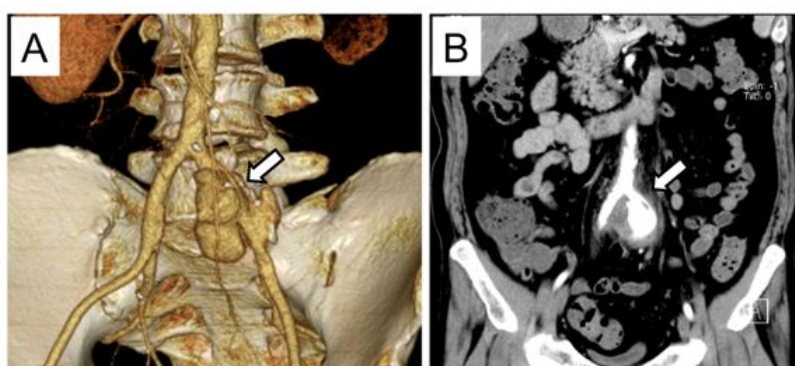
Reconstructed and coronal images of contrast-enhanced computed tomography (CT). A, Volume-rendering CT image of the left common iliac artery revealing a saccular and lobular aneurysm (arrow). B, Coronal CT image of the left common iliac artery revealing an aneurysm with periaortic infiltration and stranding (arrow). (Modified from [18])
